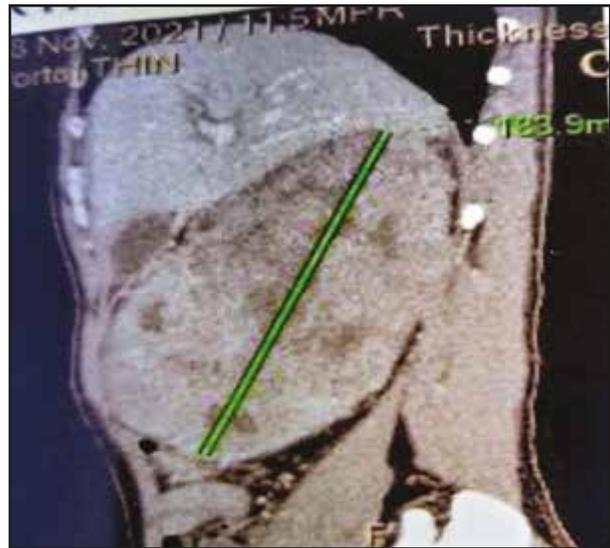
Axial contrast-enhanced CT scan image showing a large heterogeneously enhancing mass lesion in right kidney.
